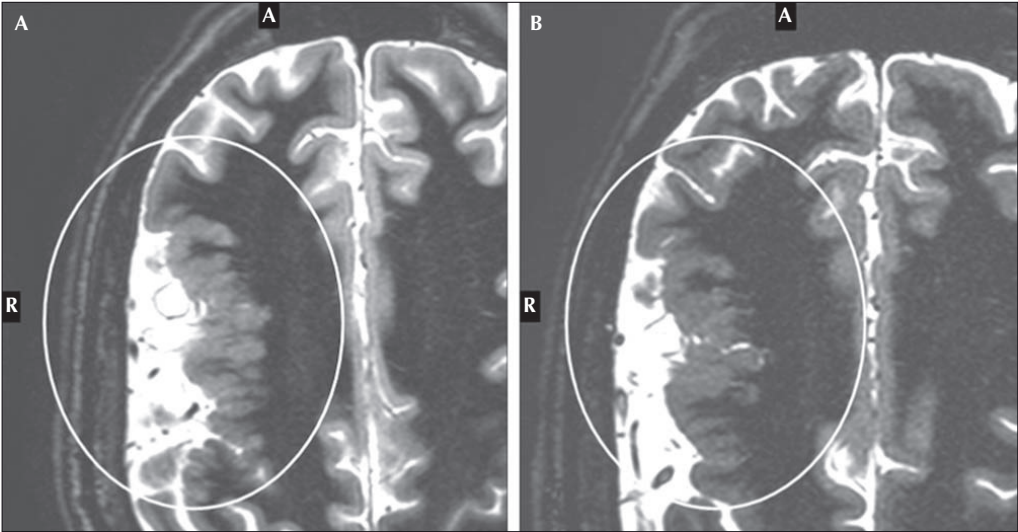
51-year-old woman with right temporal lobe epilepsy (pat # 1 in table 1) and polymicrogyria in the right frontal and temporal lobes on MRI. A), B) Magnified, axial T1w IR modulus images obtained with head coil (A) and surface coils (B) show the slightly superior demarcation on the surface coil image.
